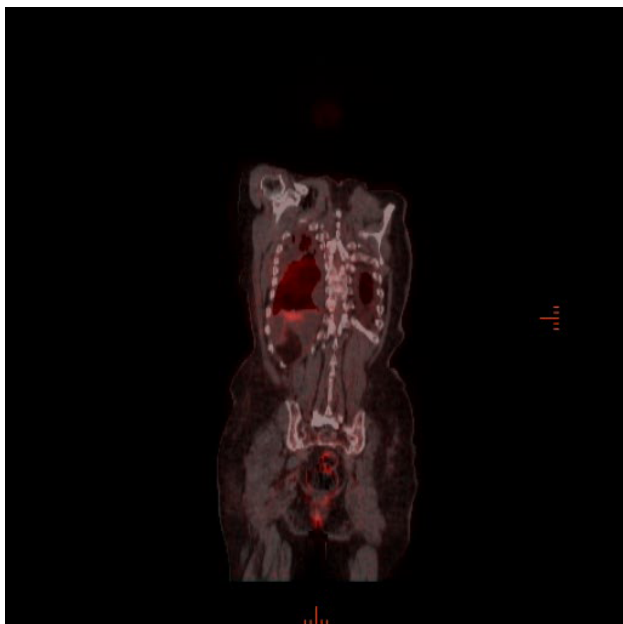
Axial cross-sectional PET/CT image of a patient with high SUV uptake in pleural effusion.
